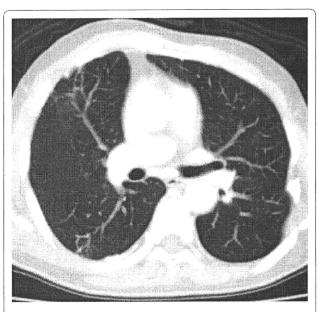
CT images before SBRT (Pt. No. 8).
